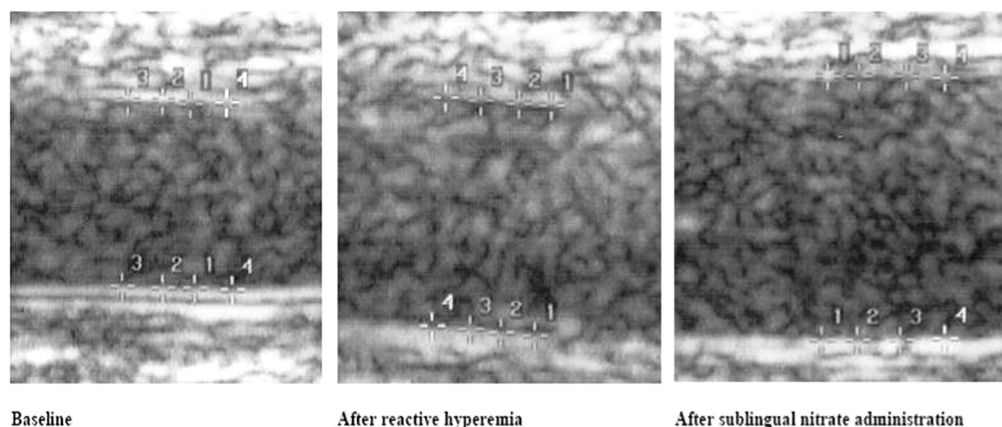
Brachial artery diameter scanning with ultrasound: at rest (baseline), after reactive hyperemia, and after sublingual nitroglycerine. Flow-mediated dilatation (FMD) and nitroglycerin-mediated dilatation (NMD) were calculated as the change in the diameter (%) relative to the baseline.
